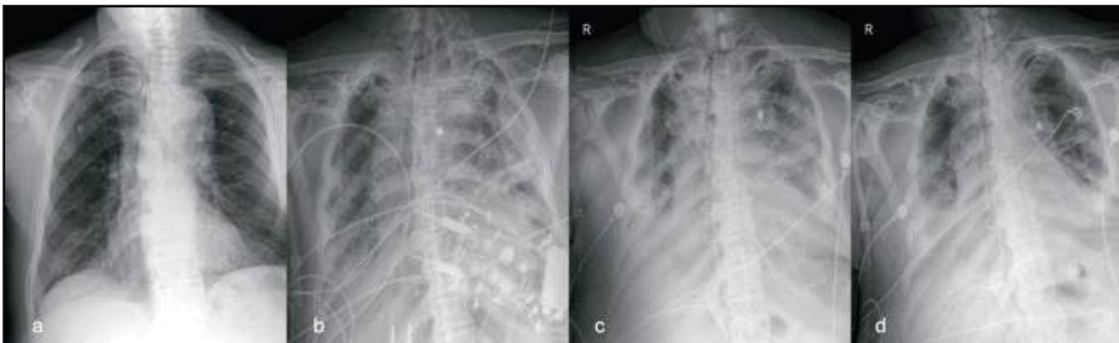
Patient's Lung Radiographs (a: Preoperative; b: Postoperative 1st day; c: Postoperative 3rd day; d: Postoperative 5th day).
